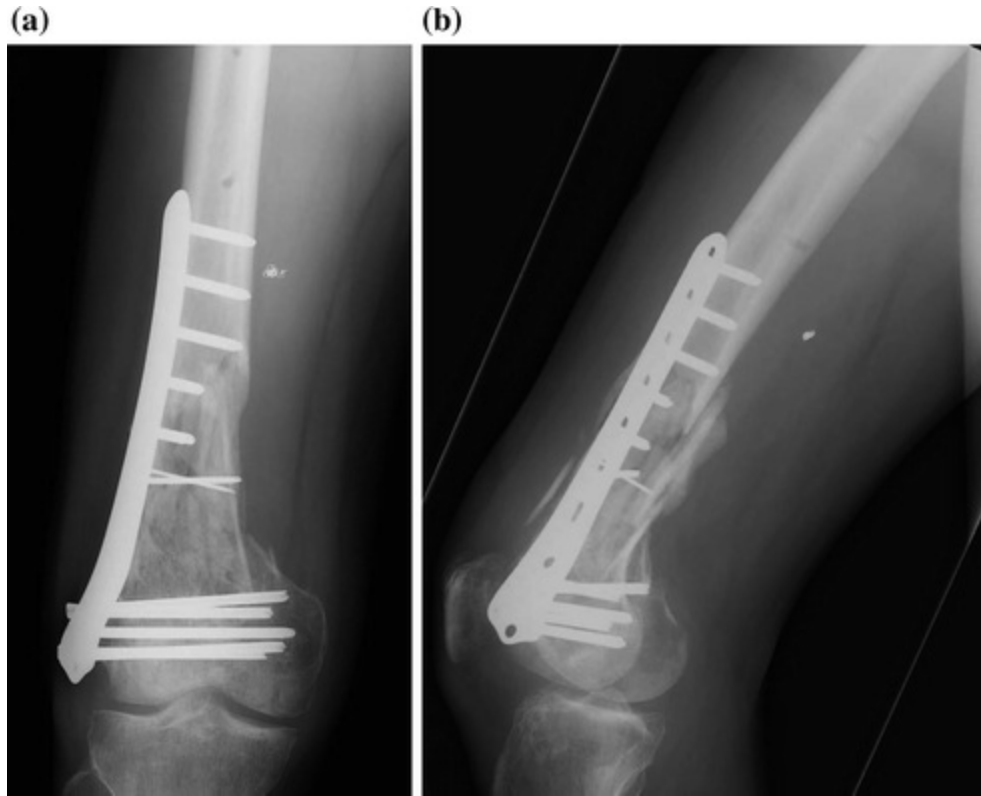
a Anteroposterior and b lateral radiographs of the right knee showing hardware failure, shortening and varus
